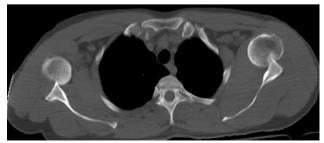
Computed tomography images of the patient.
